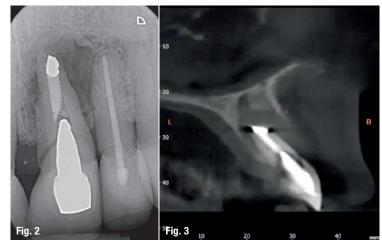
2-D radiograph. Fig. 3: 3-D radiograph.
